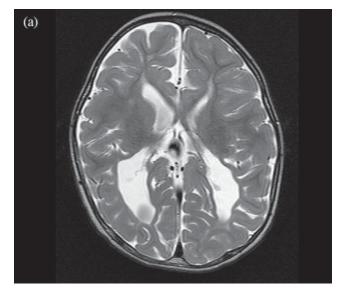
Periventricular leukomalacia observed via MRI in a 2-yearold boy. (*a*) Bilaterally enlarged occipital horns are revealed, characteristic of PVL. (*b*) In the coronal plane asymmetric enlargement of the lateral ventricles can be noted, again characteristic of PVL.
